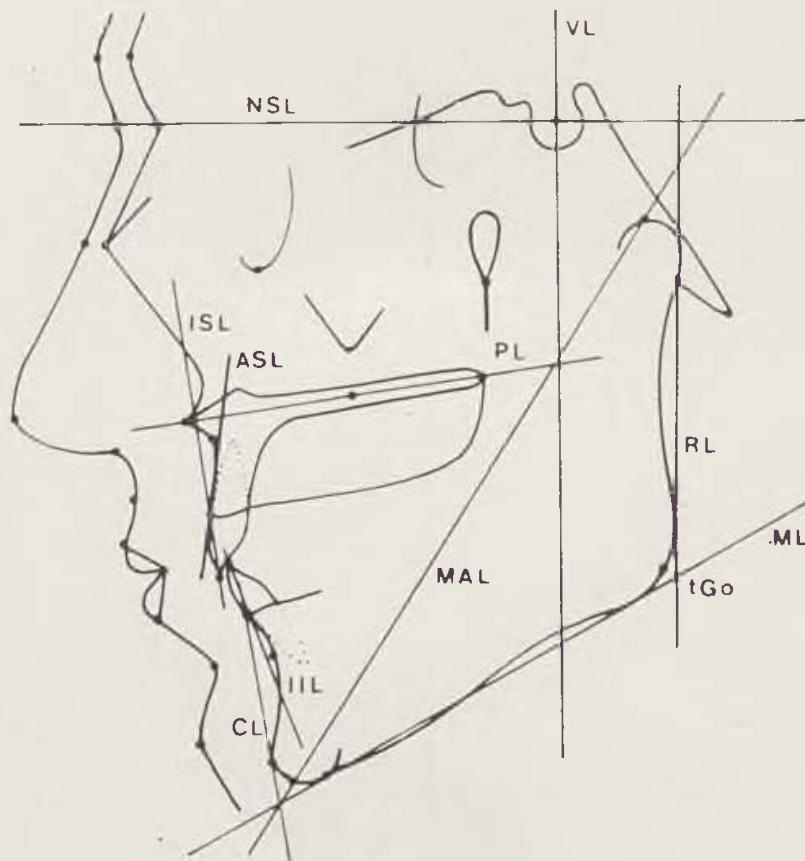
Reference lines plotted on lateral X-ray films (NSL = line through N and S, VL = perpendicular to NSL through S, PL = line through Sp and Pm, CL = line through Pg and Id, ML = tangent to the mandibular body through Gn, RL = tangent to the mandibular ramus through Ar, MAL = line through Pgn and Cd, ASL = tangent to the maxillary alveolar process through Pr, ISL = line through Is and Pr, IIL = line through Ii and Id, tGo = intersection of ML and RL).
